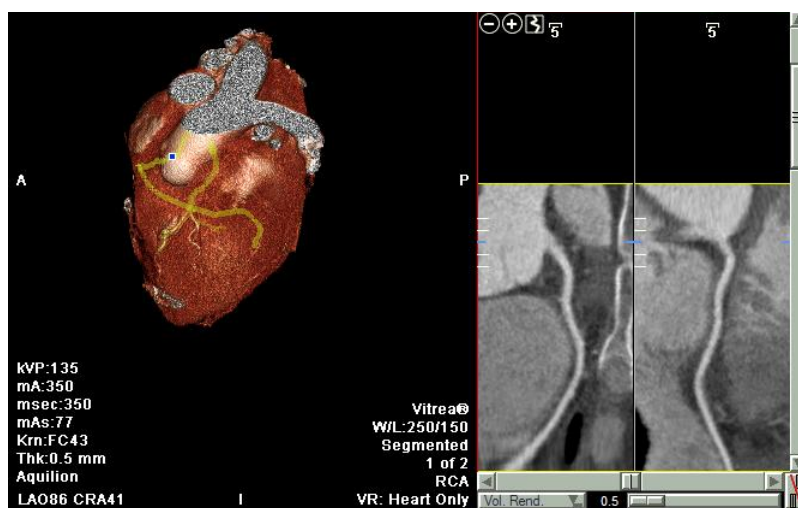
Multislice computed tomography coronarography: all coronary blood vessels are free of plaque and show no signs of stenosis.
